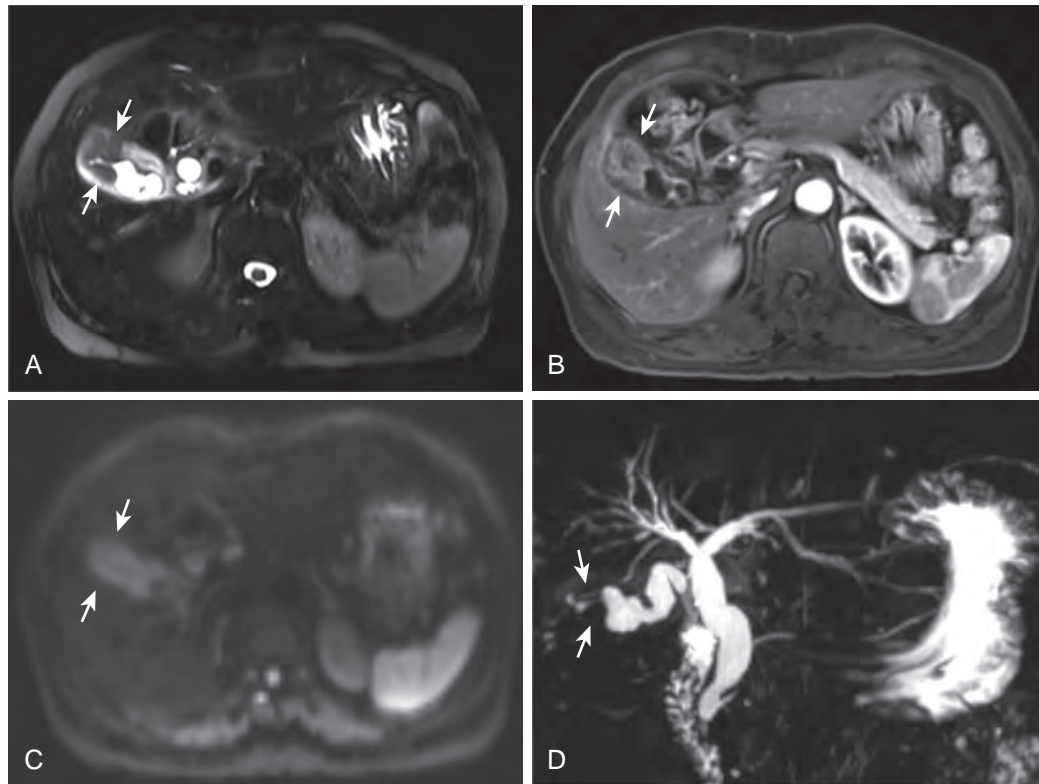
Gallbladder cancer showing enhancement on MRI and a high signal intensity on diffusion-weighted imaging. A. Fat-suppressed T2-weighted MR image shows an asymmetrically thickened gallbladder wall with hypointensity (arrows) compared with edematous surrounding wall. B. Postgadolinium fat-suppressed T1-weighted image reveals slightly heterogeneous enhancement of the thickened gallbladder wall (arrows). C. High b value ($b = 1000$) diffusion-weighted imaging demonstrates a high signal intensity of the tumor (arrows) involving the fundus of the gallbladder. D. MRCP demonstrates a luminal narrowing of the fundus (arrows) caused by the tumor and a normal appearance of the bile duct.
